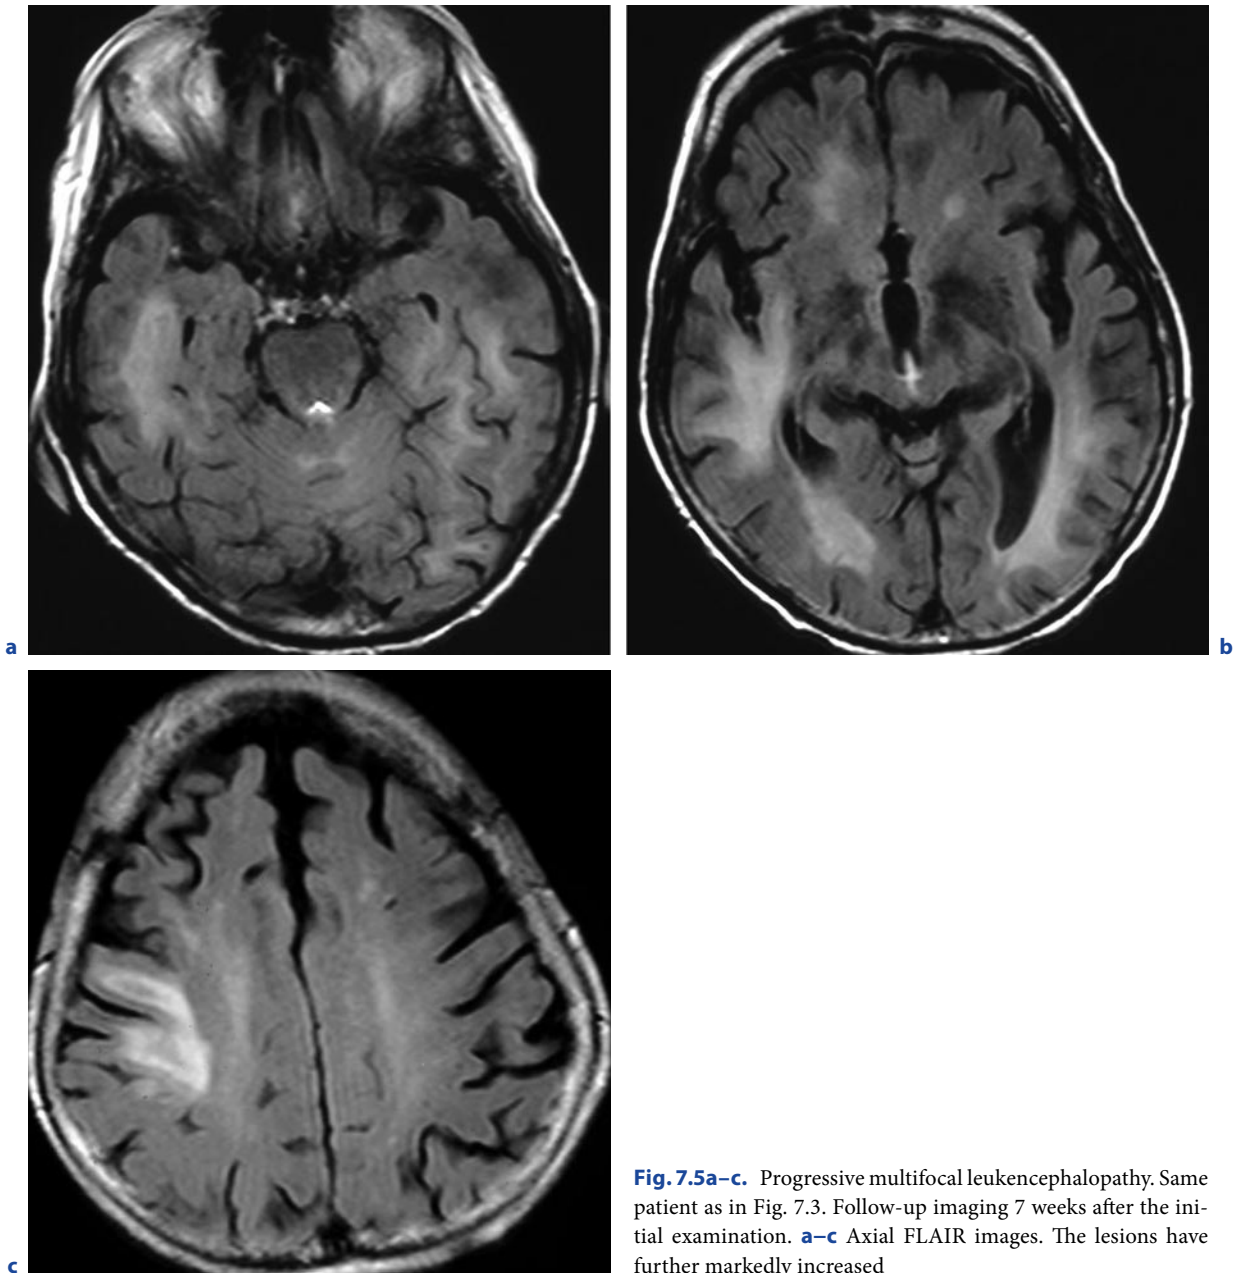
Progressive multifocal leukoencephalopathy. Same patient as in Fig. 7.3. Follow-up imaging 7 weeks after the initial examination. a–c Axial FLAIR images. The lesions have further markedly increased
